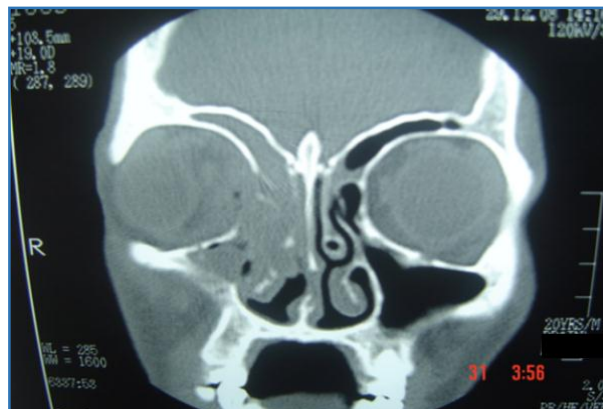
CT scan showing Haziness of Ethmoids and Maxillary Sinuses involving orbit
